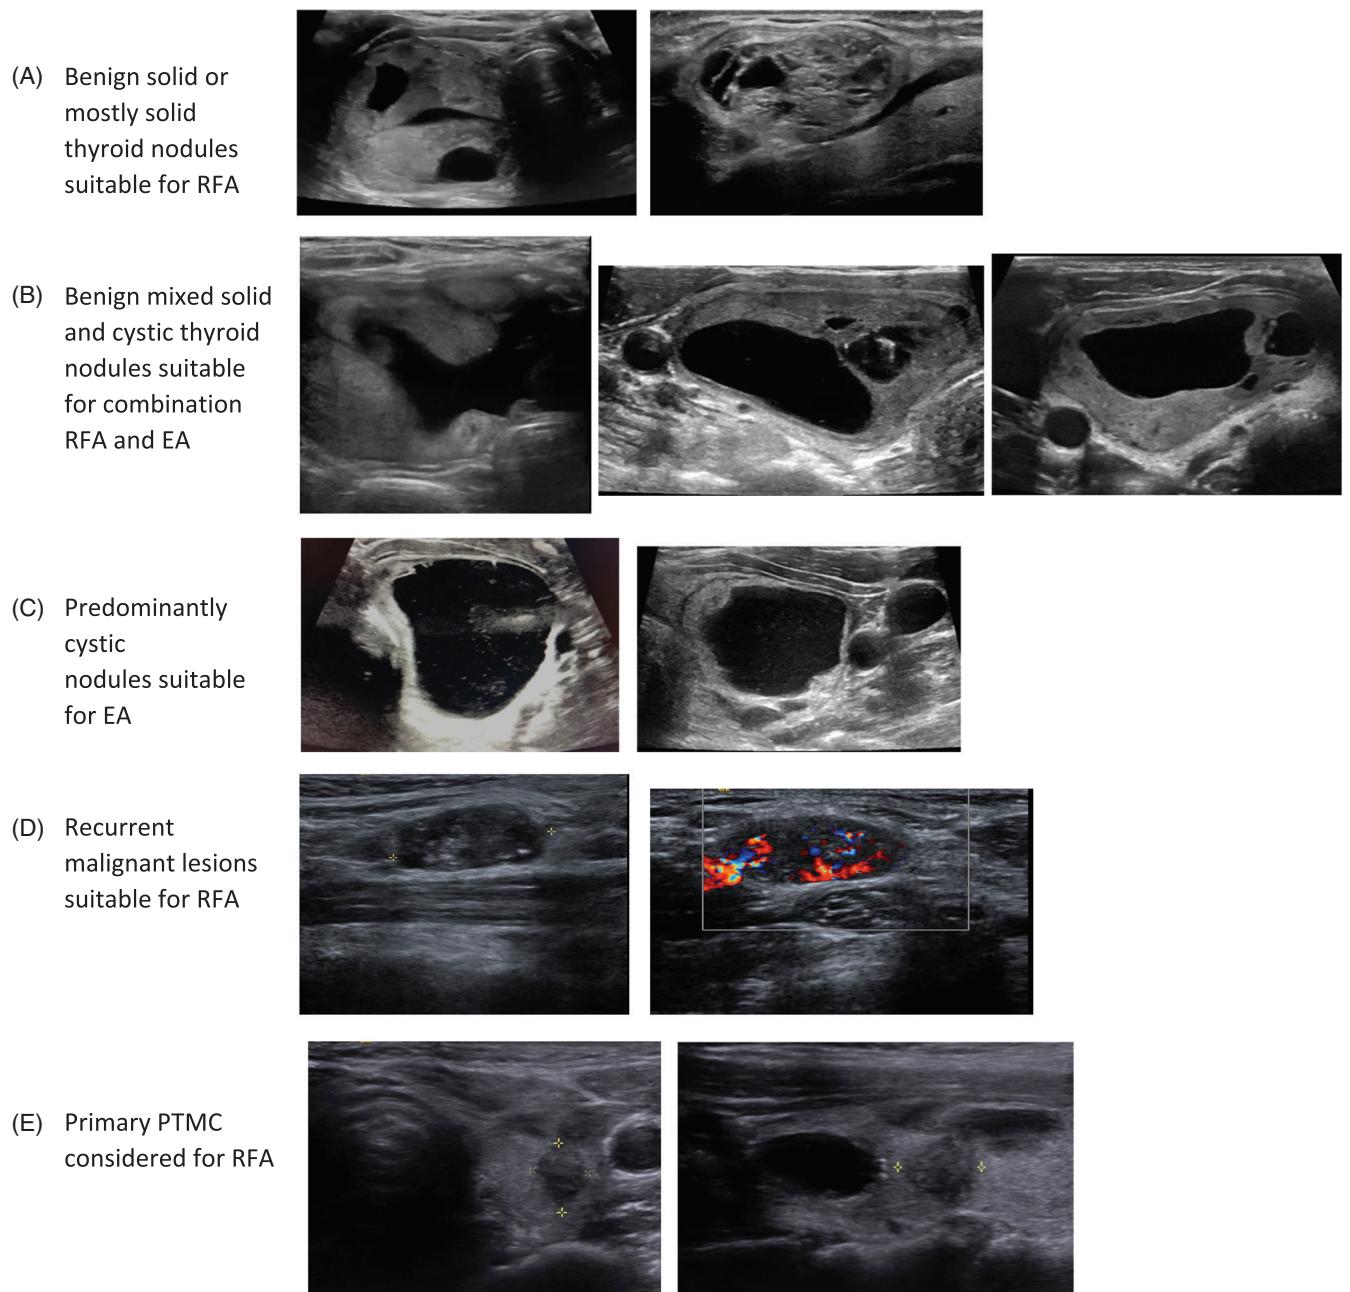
Ultrasonographic examples and recommended ablative techniques. Sonographic patterns of candidate lesions for ablation. (A) Examples of benign nodules with primarily solid or spongiform patterns that would be amenable to radiofrequency ablation. (B) Examples of mixed solid and cystic nodules with a significant cystic component best addressed with a combination of ethanol ablation (EA) for the cystic portion and RFA for the solid portion. (C) Examples of entirely or nearly entirely cystic nodules likely to be sufficiently reduced by ethanol ablation (EA) alone. (D) Examples of isolated recurrent papillary thyroid carcinoma in lateral neck lymph nodes, amenable to RFA. (E) Example of a unifocal papillary thyroid microcarcinoma without adverse features or radiographic evidence of metastatic disease, amenable to RFA
